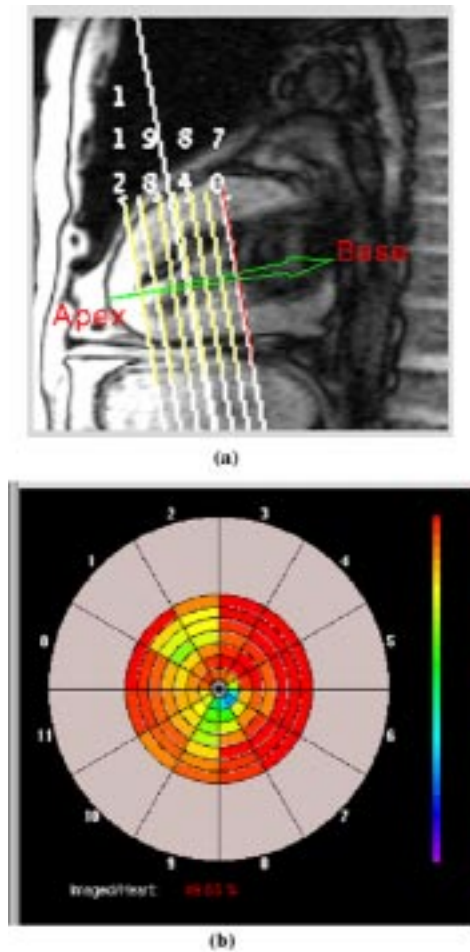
Partial polar map. (a) An MRI scout view is used to point at the apex, the base, and first imaged plane. (b) The relative positions of the MRI plane on a partial polar map.
